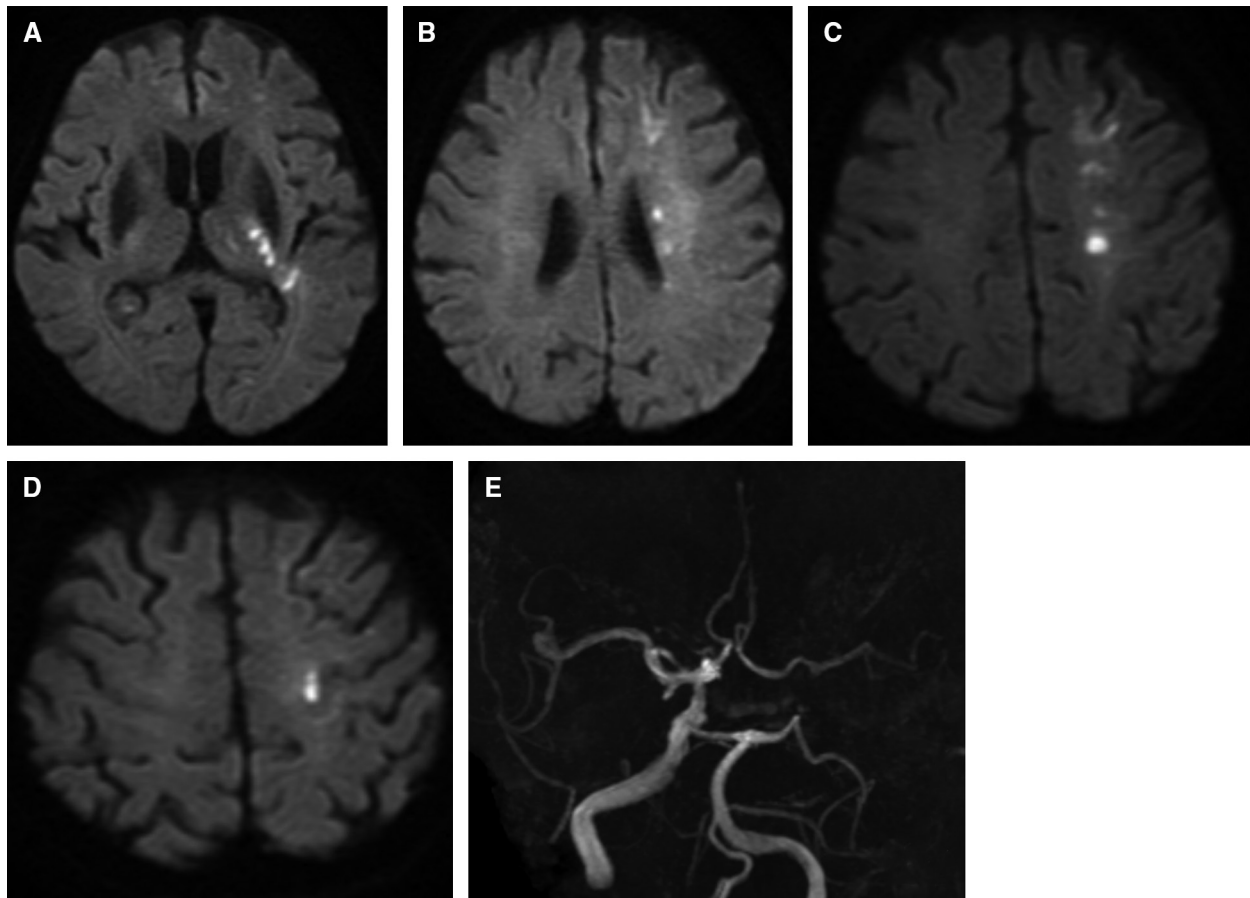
DWI the day after treatment showed a high-intensity lesion at the territory of anterior choroidal artery (A), left corona radiata (B), and the watershed area of anterior cerebral artery middle cerebral
